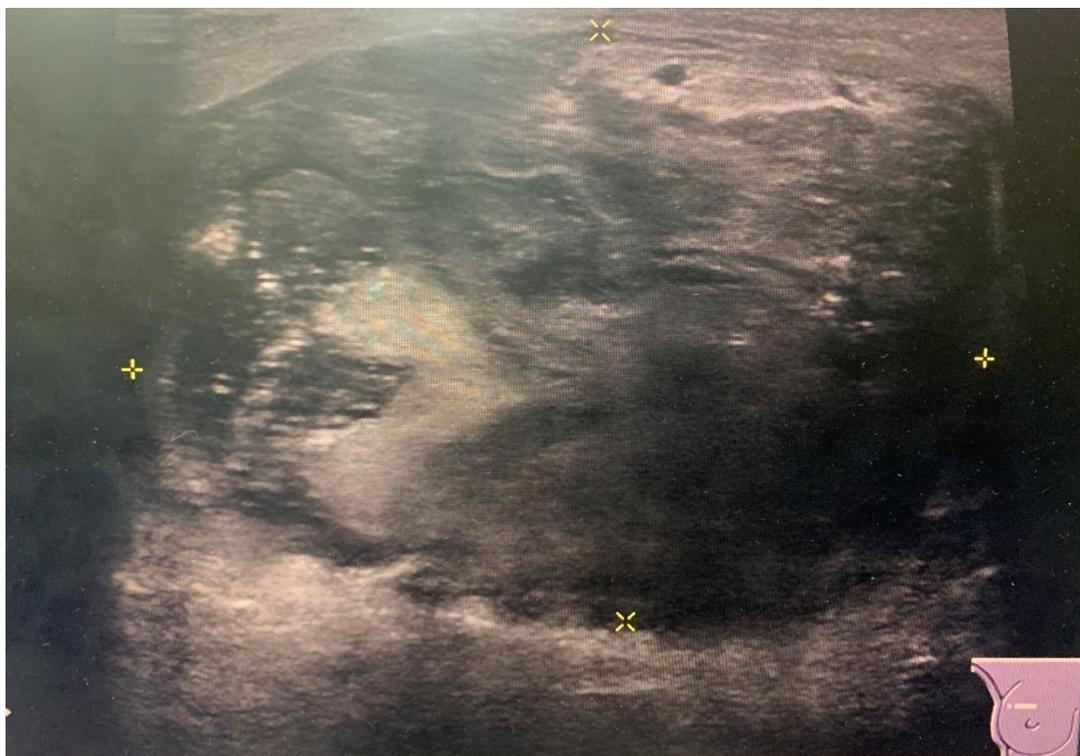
Breast US with heterogeneous lesion in the upper outer quadrant of the right breast measuring 56x40x70 mm with a volume of 86 cc with central and peripheral enhancement on Doppler BI-RADS 4
